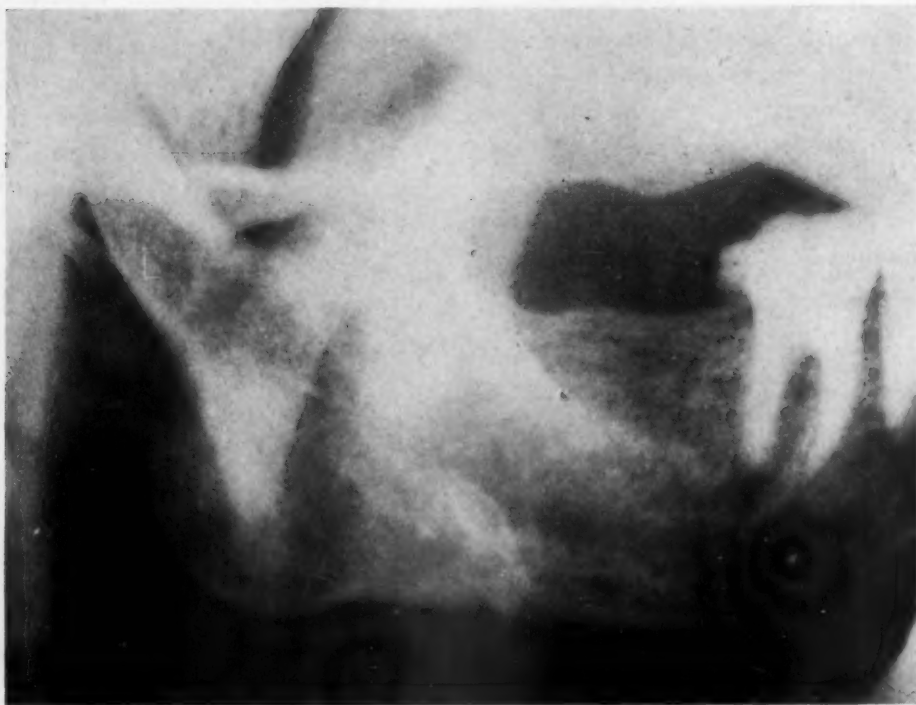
X-ray showing fracture of ramus of mandible.
